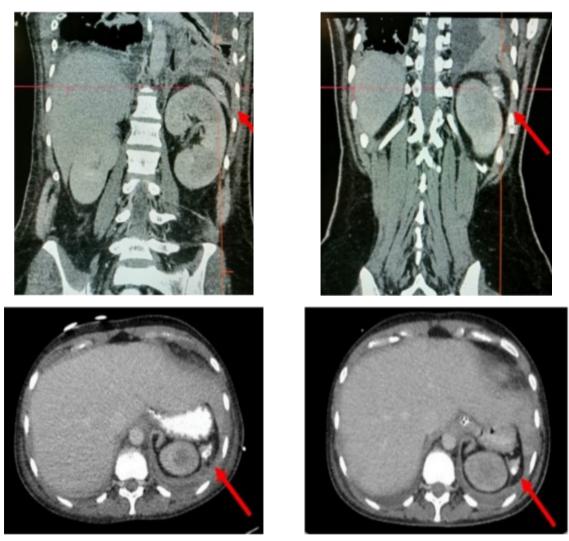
Coronal and axial view of patient's CT abdomen pelvis
